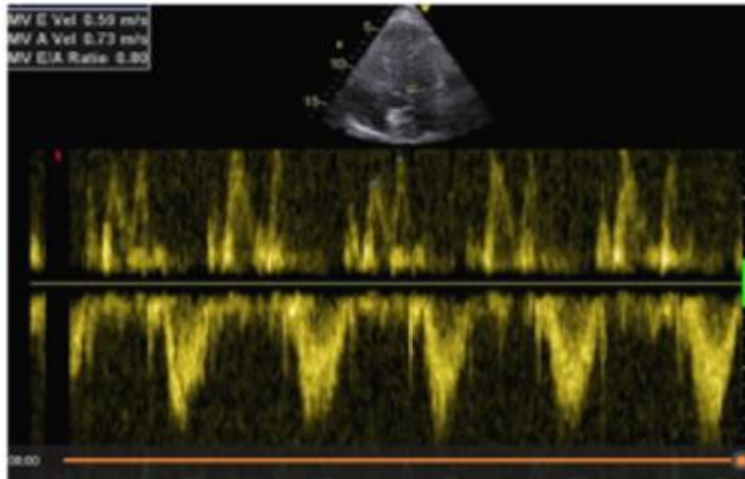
Assessment of LV diastolic function by conventional pulsed –Doppler.
